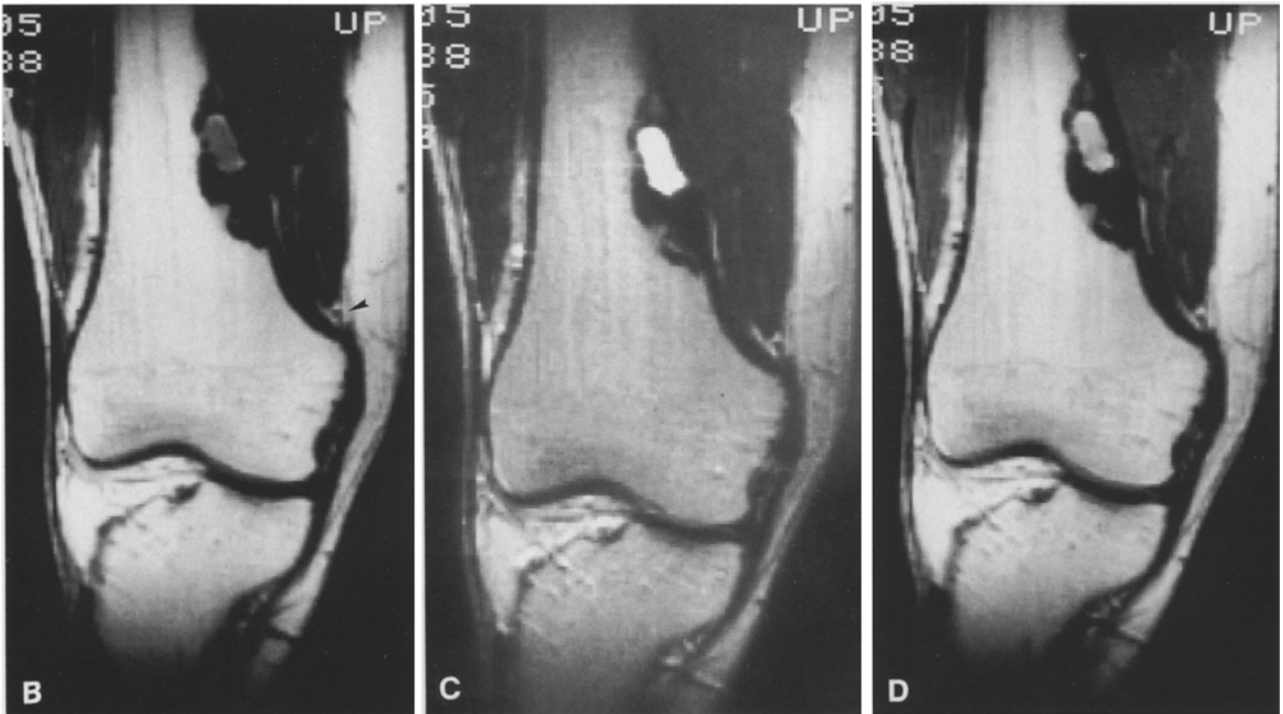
A, B. *HB 16-year-old-female.* A Plain radiograph (lateral) of left distal femur: fibrous metaphyseal defect at stage B. B Parasagittal MRI (SE 700/15) through the distal femur. The fibrous metaphyseal defect (stage B) displays multiple areas of homogeneous structure with pseudotrabeculae. A purely cystic fibrous metaphyseal defect was verified operatively. Note chemical shift artifact (→)
